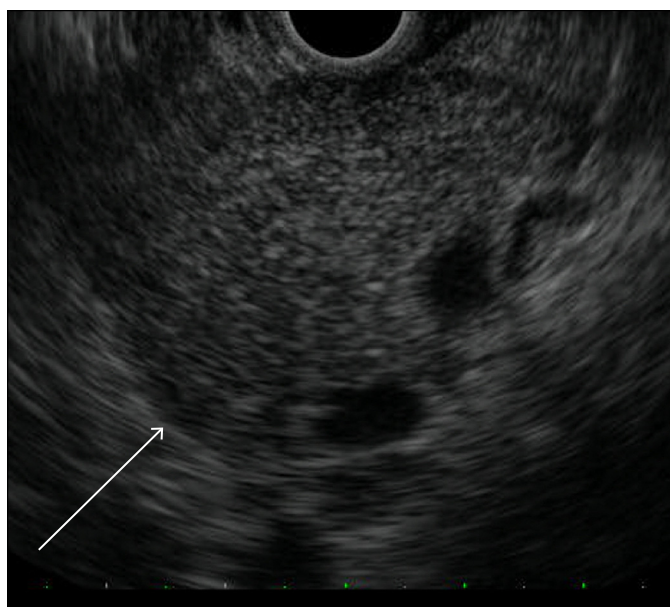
Endoscopic ultrasound showing diffusely enlarged pancreas with hypoechoic parenchyma and narrowed main pancreatic and common bile ducts.
